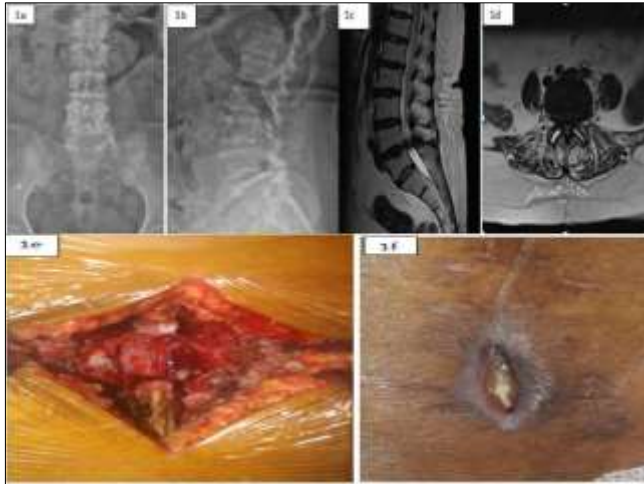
AP (1a) and lateral (1b) X-rays in standing position showing degenerative changes and decreased disc height at L4-5. T2 midsagittal (1c) and T2 axial (1d) MRI picture showing severe canal compromise with ligamentum flavum hypertrophy. Intraoperative photograph after decompression (1e) and a case of deep wound infection after laminectomy for LCS (1f).
